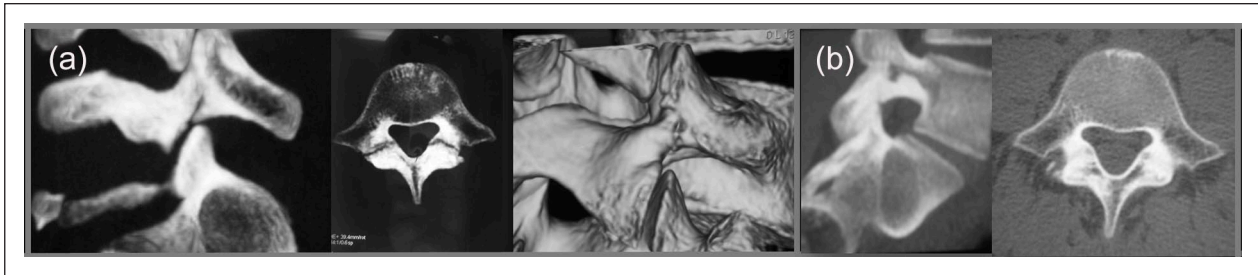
(a) L5 spondylolysis diagnosed by CT in a 12-year-old male patient. (b) After 6 months of conservative treatment with activity restriction, nonsteroidal anti-inflammatory medications and a soft brace, bony union, and total symptom resolution were achieved.
